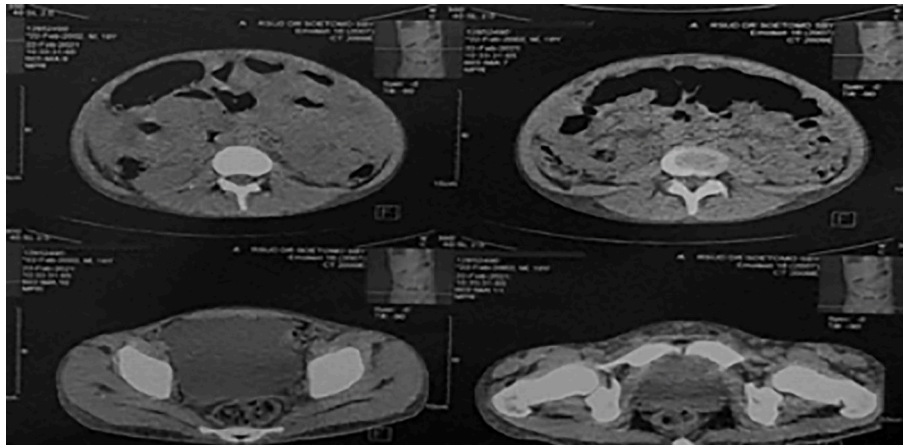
Axial contrast-enhanced CT: Mild ascites; thickening of the peritoneum, omentum, and small bowel's wall; adhesion of small bowel, mesenteric, and omentum.
